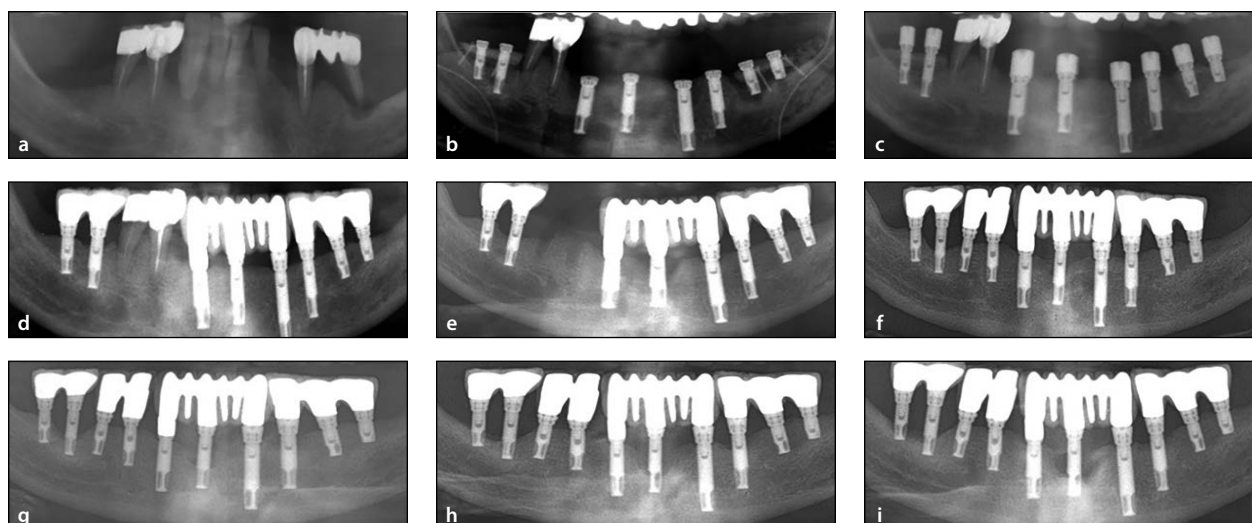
Panoramic radiograph of the patient with bilateral onlay graft in posterior mandible. (a) Preoperative panoramic radiograph showing partial edentulism in bilateral posterior mandible with a vertical defect. (b) Immediate postoperative radiograph. Implants were placed simultaneously with onlay bone grafts. (c) Panoramic radiograph taken after stage-two surgery of the submerged implants (6 months after implant placement). (d) Panoramic radiograph taken 1 year after the placement of the implant. Right mandibular first molar showed increased marginal bone loss. Panoramic radiograph taken (e) 3 years, (f) 5 years, (g) 12 years, (h) 14 years, and (i) 16 years after the placement of the implant. Right mandibular first and second molars were considered implant failures at 14 years, while left mandibular implants were successful for 16 years. Failed implants (right first molar) showed peri-implant bone loss, while adjacent implants (right second molar) in the same grafted bone were intact for 9 years. This patient had periodontitis of adjacent teeth (right first and second premolars), which were extracted 3 years after implant placement.
